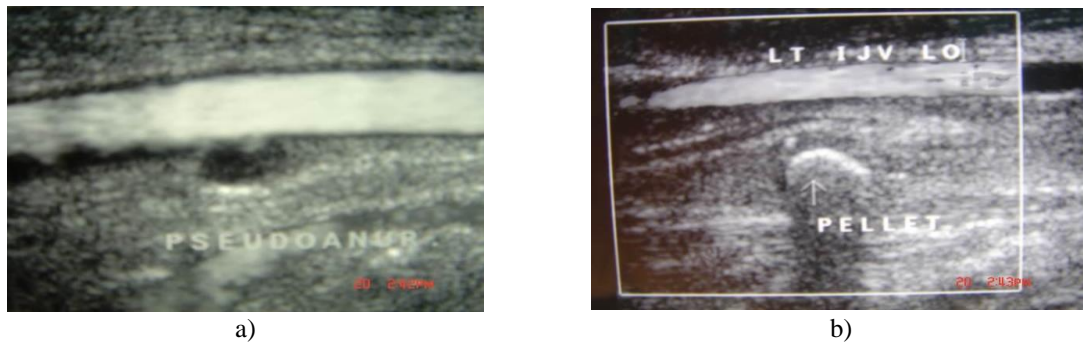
Duplex ultrasound, a small area of the pseudo-aneurysm at the wall of the left CCA and the site of the air-gun bullet deep into the muscle just posterior to the left IJV
